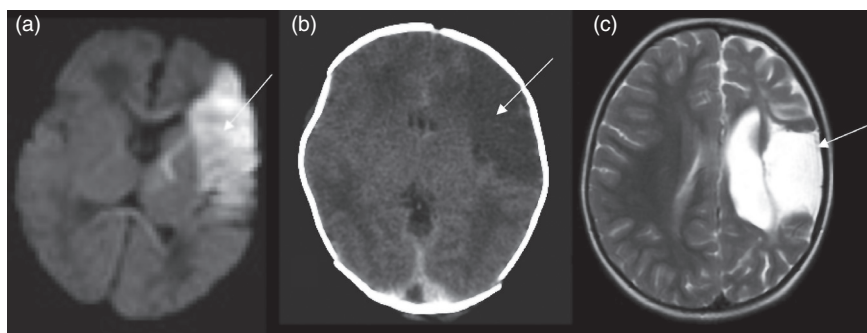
Middle cerebral arterial infarction (arrows): (a) acute phase with edema on axial DWI; (b) subacute phase on CT; (c) chronic phase on axial T2 with hemiatrophy.
